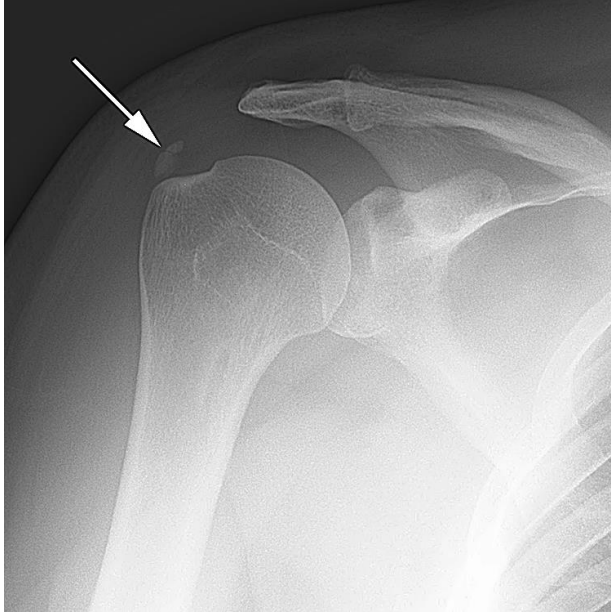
Calcific tendinitis in a 48 year old man with shoulder pain. AP plain film exam demonstrates calcification along the distal aspect of the supraspinatus tendon near its insertion on the greater tubercle (arrow).
